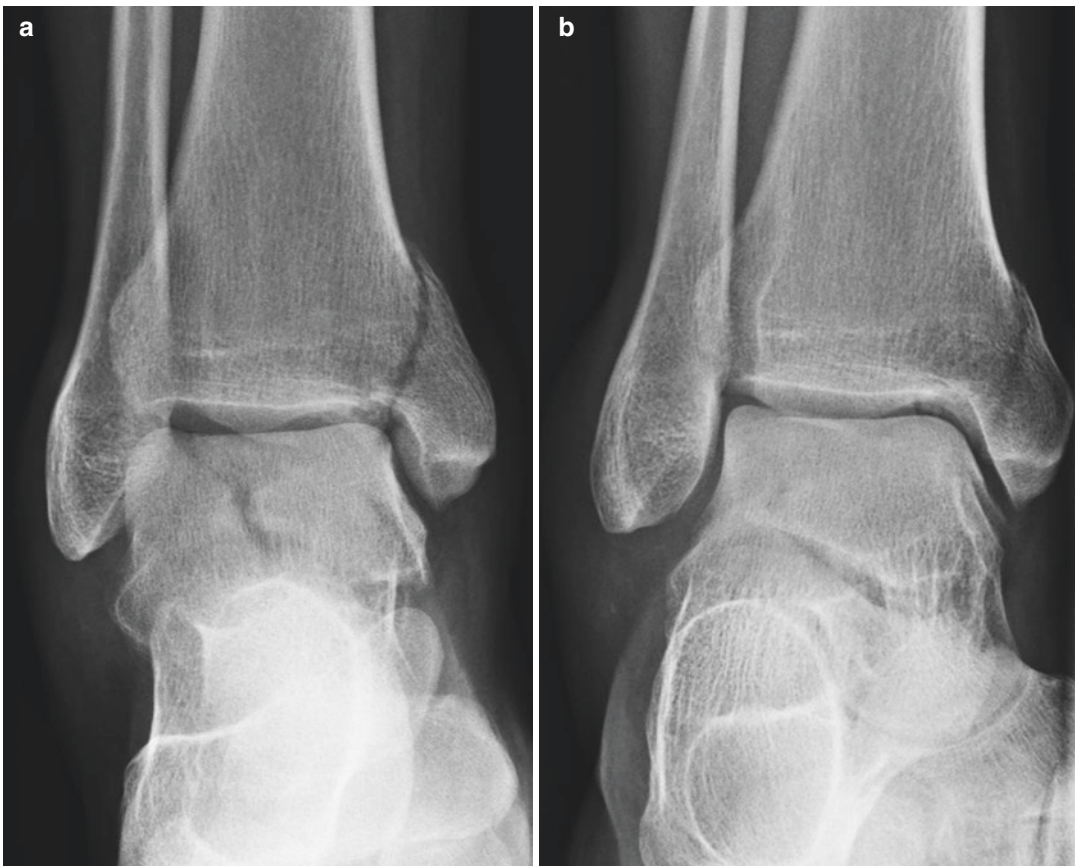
Injury ankle radiographs of a lateral talar body fracture in association with a medial fracture of the tibia plafond. Anteroposterior, mortise, and lateral views are shown (a–c). Open reduction and internal fixation of the talar body was performed through an anterolateral exposure (d, e), promoting visualization of the lateral aspect of the talar body including the dome. Direct reduction was obtained, and provisional
